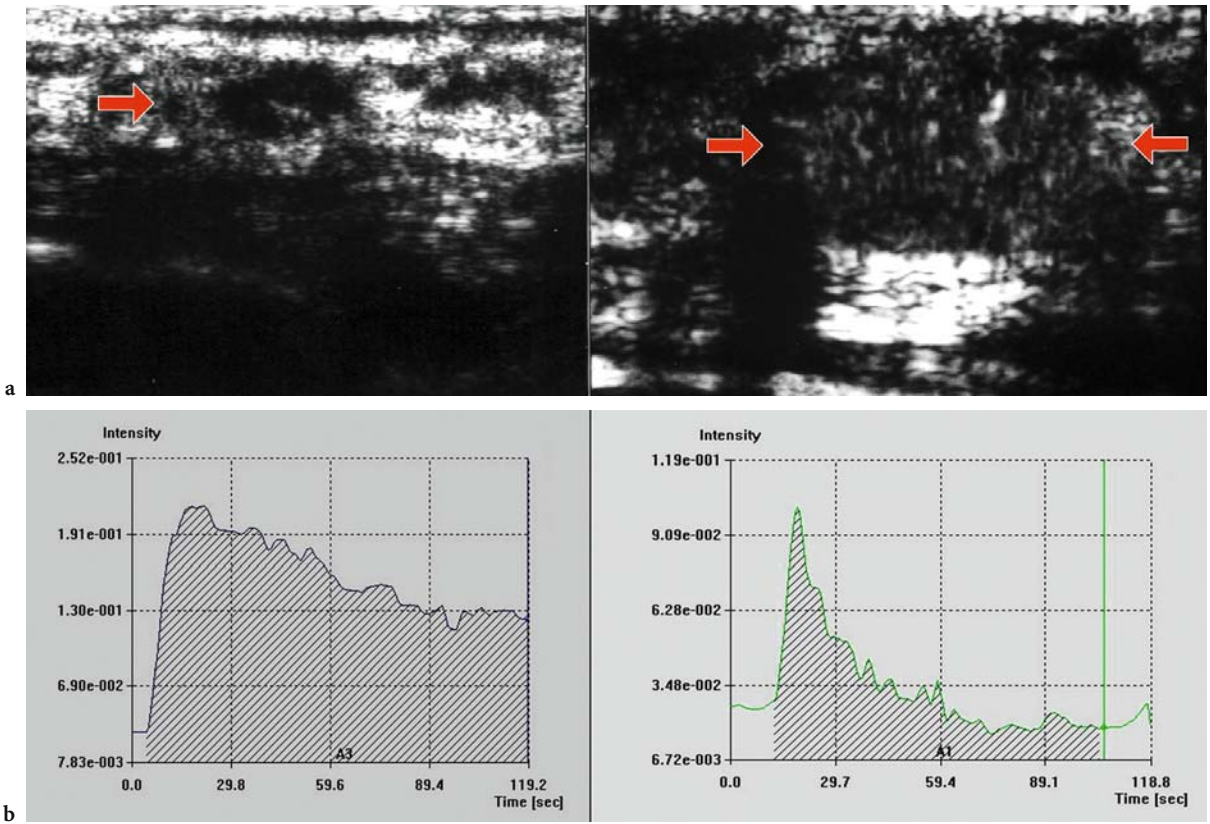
a Ultrasound scan before and after echo-amplifiers (marked increase of the acoustic signal in the lesion). b Wash-in/wash-out curve in the benign lesion (slow initial increase in enhancement and slow wash-out) and in the malignant lesion (fast initial increase in enhancement and fast wash-out)
